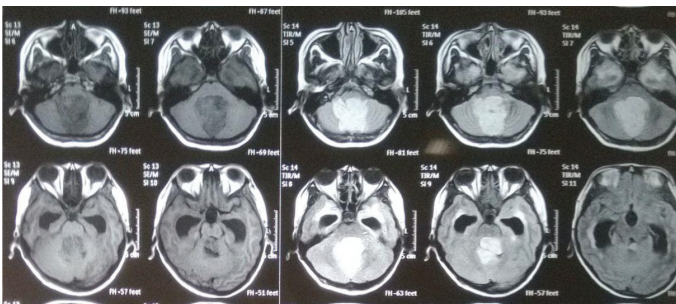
T1 and T2 MRI of medulloblastoma case
